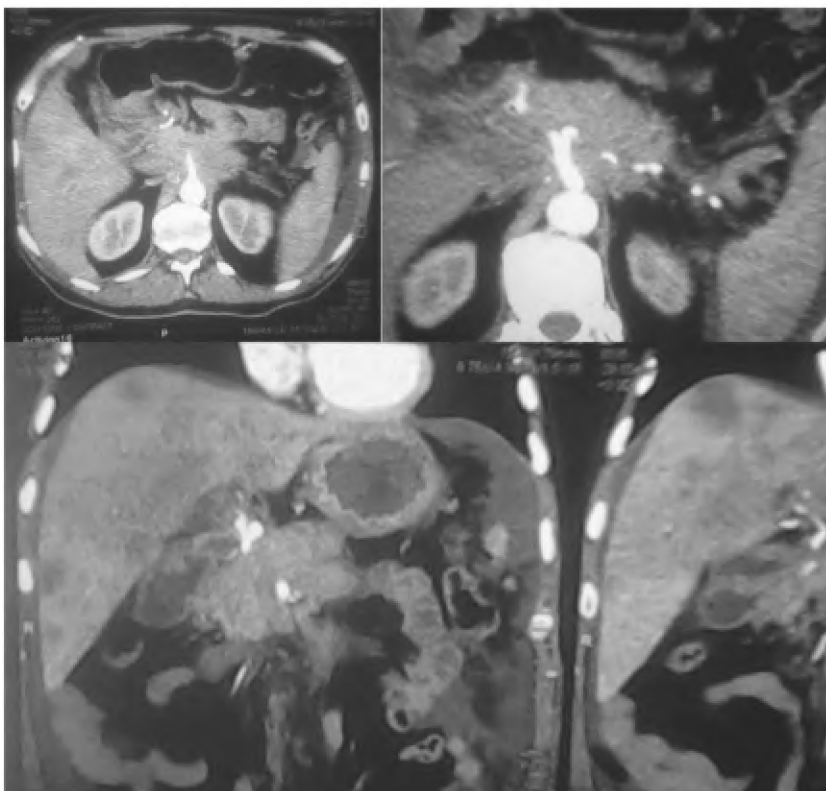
60 years old male presented with vague abdominal pain. Multislice CT showed heterogeneously enhancing pancreatic body lesion, encasing the celiac trunk and superior mesenteric artery infiltrating the posterior gastric wall as well as the duodenal wall with multiple hepatic focal lesion confirmed by fine needle aspiration biopsy as adenocarcinoma.
